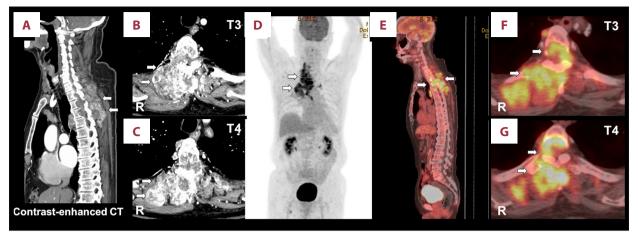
Preoperative contrast-enhanced computed tomography (CT) images (A-C) and positron emission tomography (PET) images (D-G) of the spine indicating multiple mass lesion at C7-T5 level. (A) A right-sagittal CT image showing vertebral body osteolysis and partly enhanced mass lesion at T3 and T4. (B, C) Axial CT images showing partly enhanced mass lesion invading rib, vertebrae, and spinal canal at T3 (B) and T4 (C). (D) A coronal PET image showing 18-labeled fluorodeoxyglucose accumulation. (F, G) Axial PET images showing 18-labeled fluorodeoxyglucose accumulation at T3 (F) and T4 (G). White arrows indicate the tumor.
